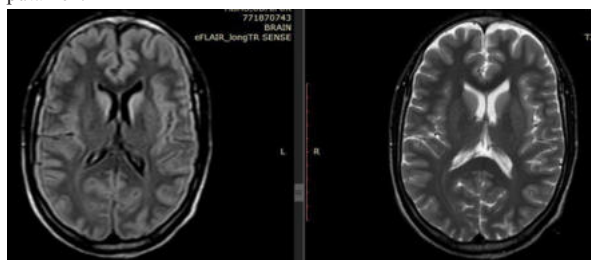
FLAIR SequenceFigure 6B:- T2W Sequence
